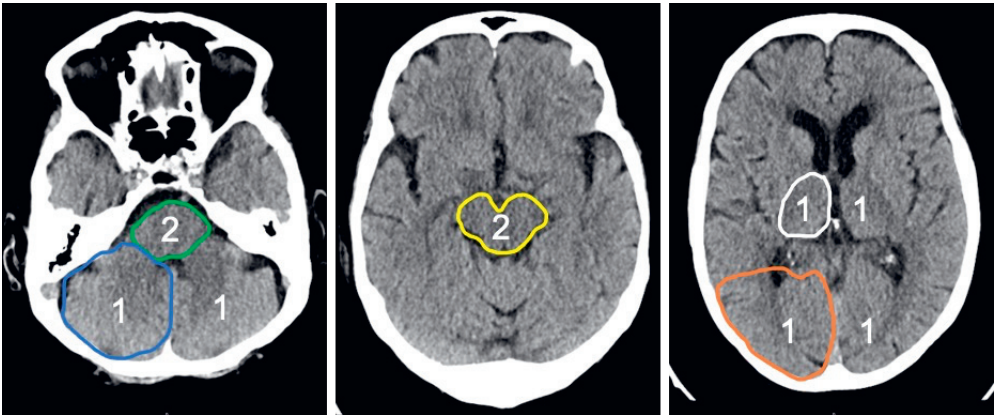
pcASPECTS areas of posterior circulation: 1 point for the left or right thalamus (white), cerebellum (blue) or PCA territory (orange); 2 points for any part of the midbrain (yellow) or pons (green).
